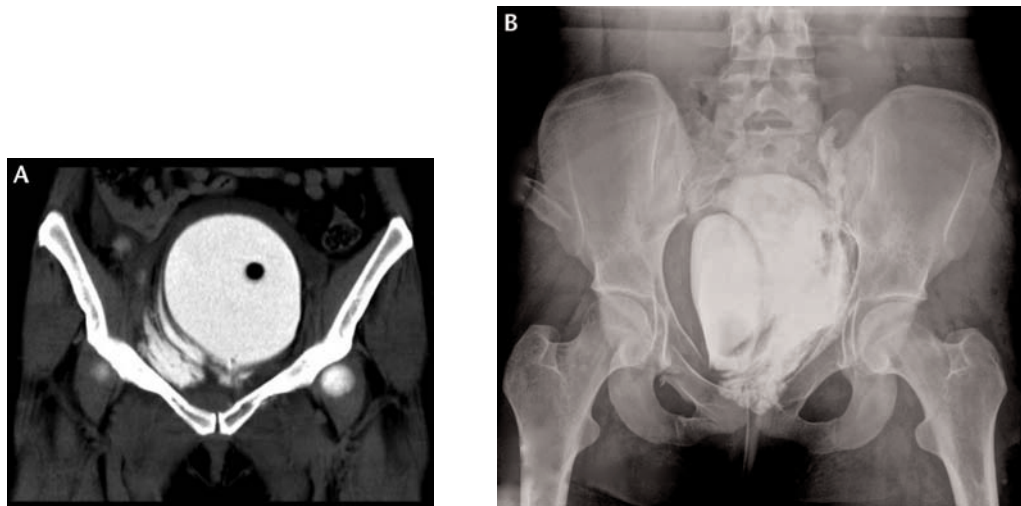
(A) Extraperitoneal (EP) contrast extravasation on computed tomography cystogram. (B) EP injury with contrast tracking giving the appearance of intraperitoneal contrast extravasation.
